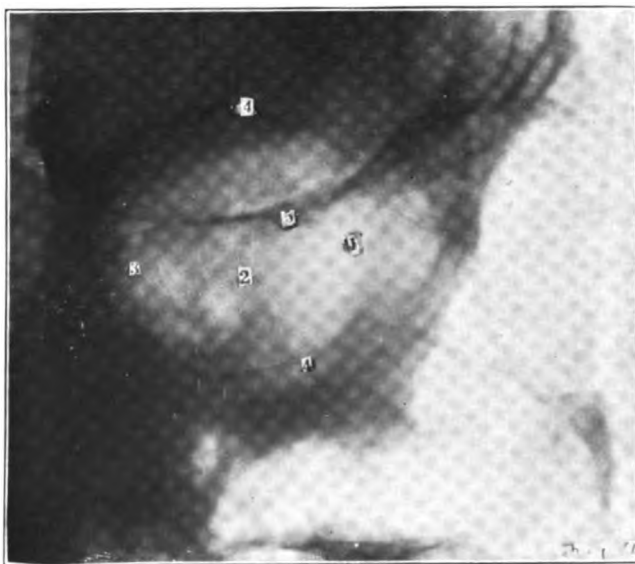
Roentgenogram showing involvement of 1, anterior, and 2, posterior ethmoids, and 3, the sphenoid. 4, 4, orbital margin; 5, suture line (right side).
